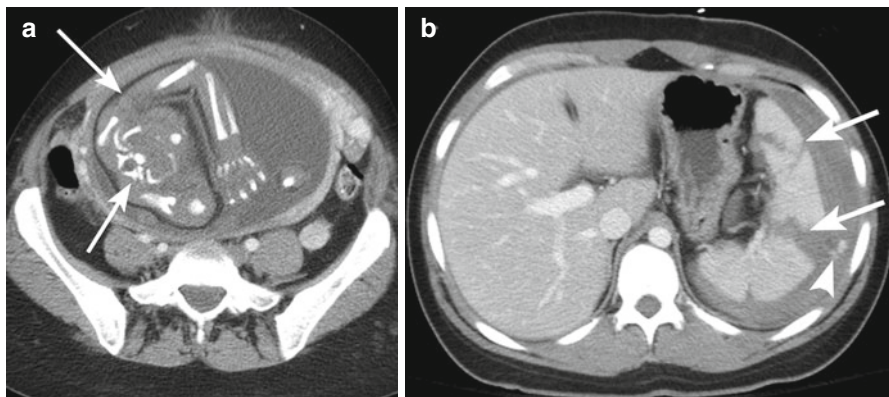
(a) Post-contrast computed tomography (CT) of the pelvis shows a fetus within the gravid uterus (*arrows*). (b) More superiorly, there are multiple splenic lacerations (*arrows*) and focal active hemorrhage (*arrowhead*) with peri-splenic hematoma
